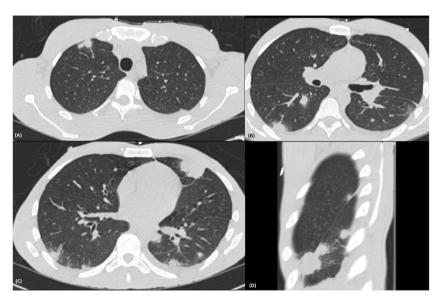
High resolution CT of the chest remonstrating the nodules with feeding vessel sign.
